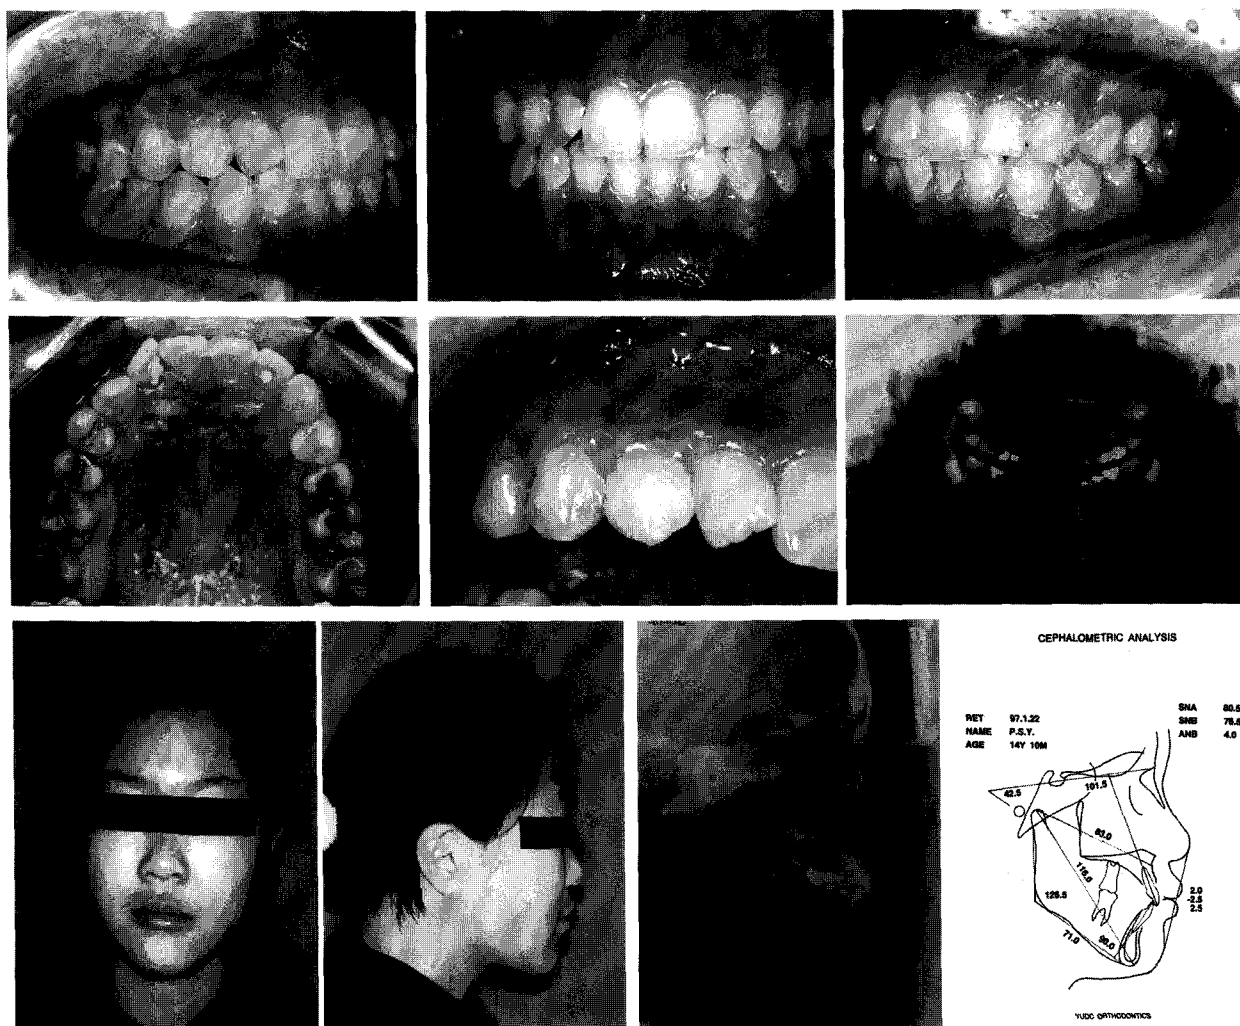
Case 1. Intraoral photos, facial photos, and X-rays at 1.5 year retention period
